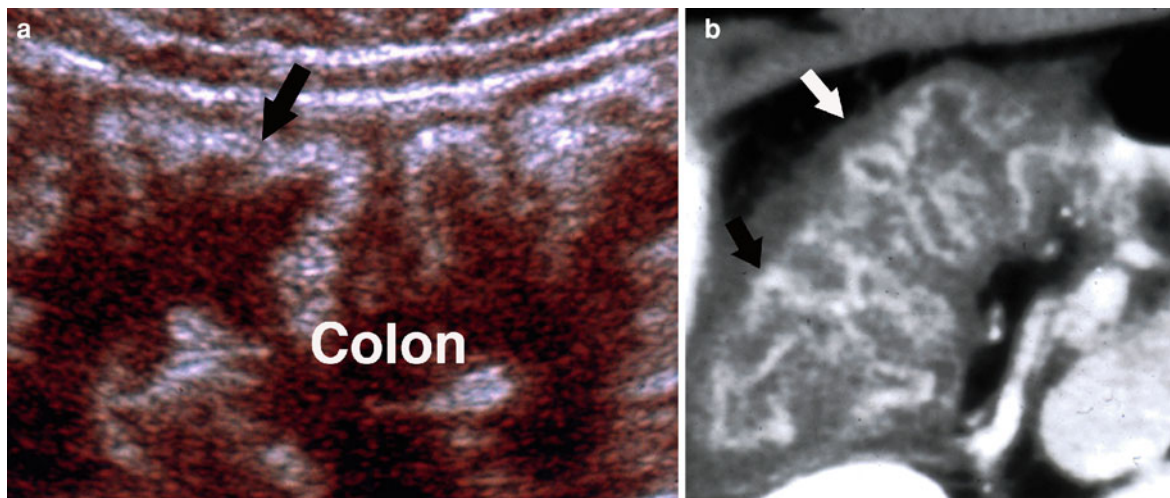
a, b Pseudomembranous colitis mimicking appendicitis. In a, longitudinal grayscale sonogram of right colon, note marked mural thickening and prominence of echogenic submucosal layer, indicating submucosal edema (*white arrow*). b is contrast-enhanced CT in same patient demonstrating
